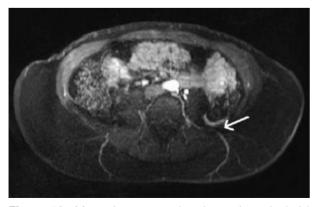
Magnetic resonance imaging angiography (axial view) demonstrating a left septocutaneous lumbar vessel.
